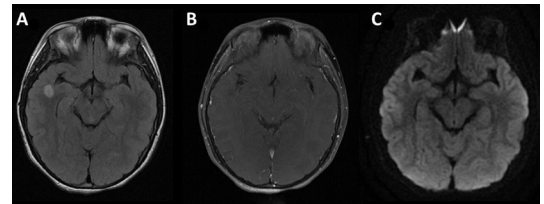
Neuroimaging features of low-grade neuroepithelial tumour. MRI reveals a hyperintense temporal lobe mass on fluid-attenuated inversion recovery sequences (A), without post-gadolinium enhancement (B) or reduced diffusivity (C).
